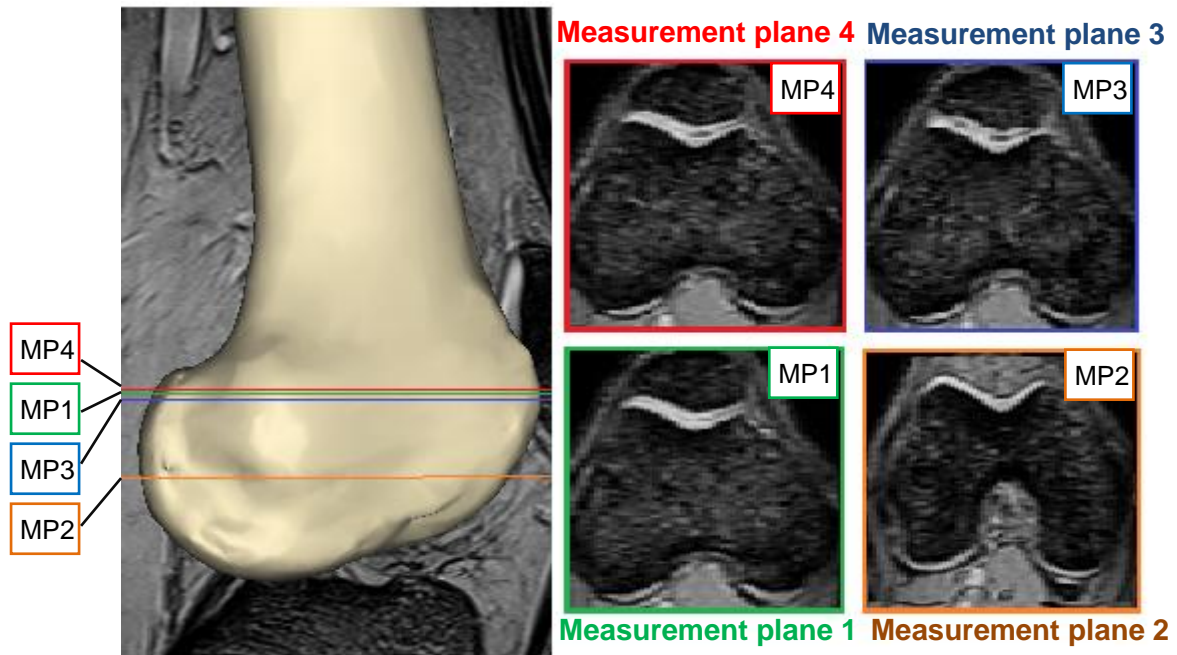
MR image of measurement planes of the same femur
